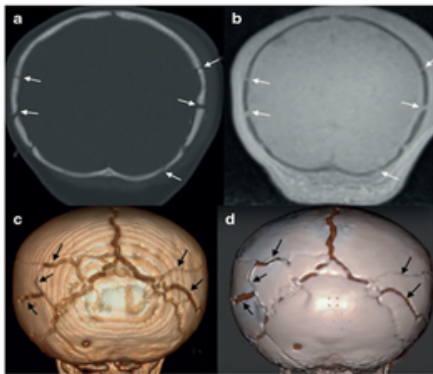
A 9-month-old patient with several skull fractures on CT head (a), and black BB MRI (b) and the corresponding 3D scan (c, d).
